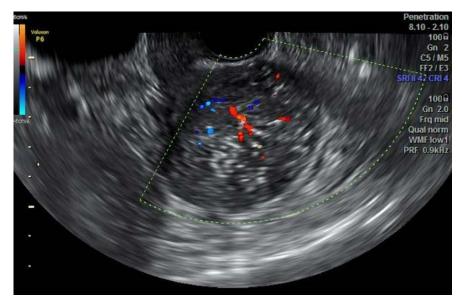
Endovaginal ultrasound image demonstrating a large uterine corpus tumour with extensive myometrial infiltration
